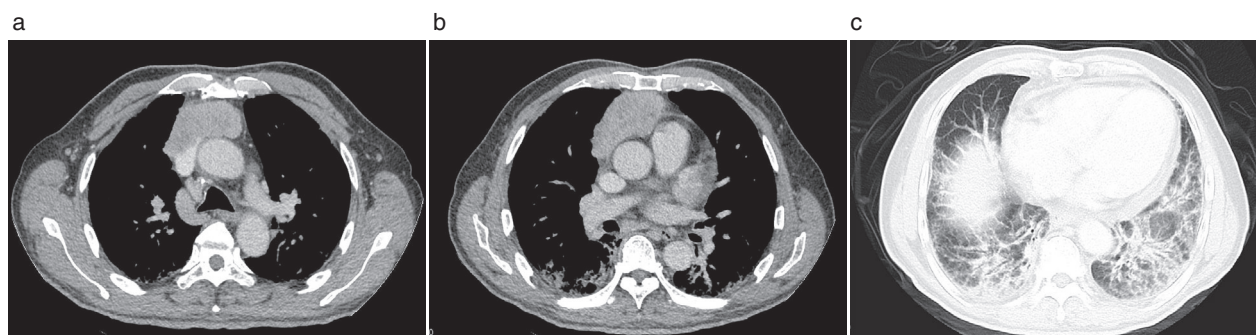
Computed tomography of the chest showing an anterior mediastinal tumor measuring 7.4 × 9 × 3.7 cm, as well as interstitial pneumonia (IP).
